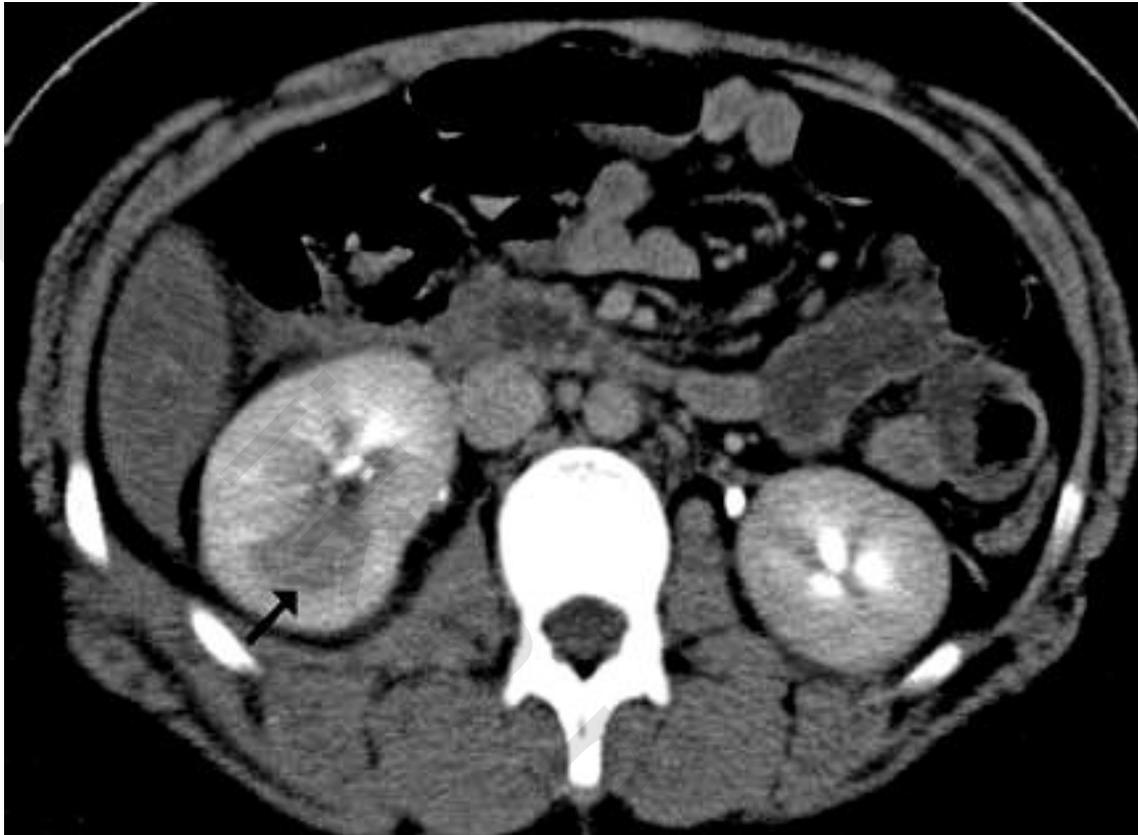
Right renal contusion (grade I renal injury). Axial enhanced CT image shows a focal area of decreased enhancement (arrow) in the right kidney. ⁽³⁸⁾
